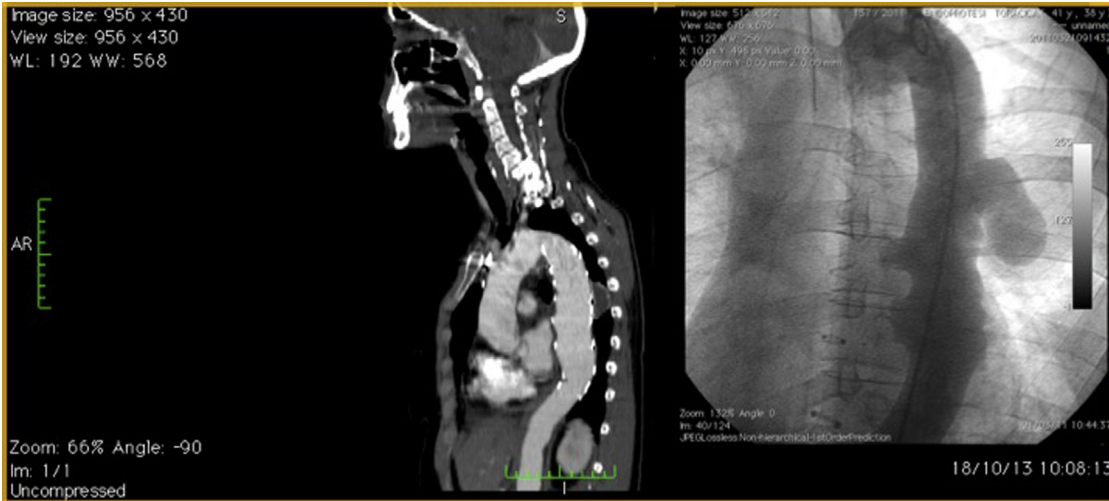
Thoracic aorta aneurysm: preoperative angiography and postoperative angio CT scan (4-year follow-up).
